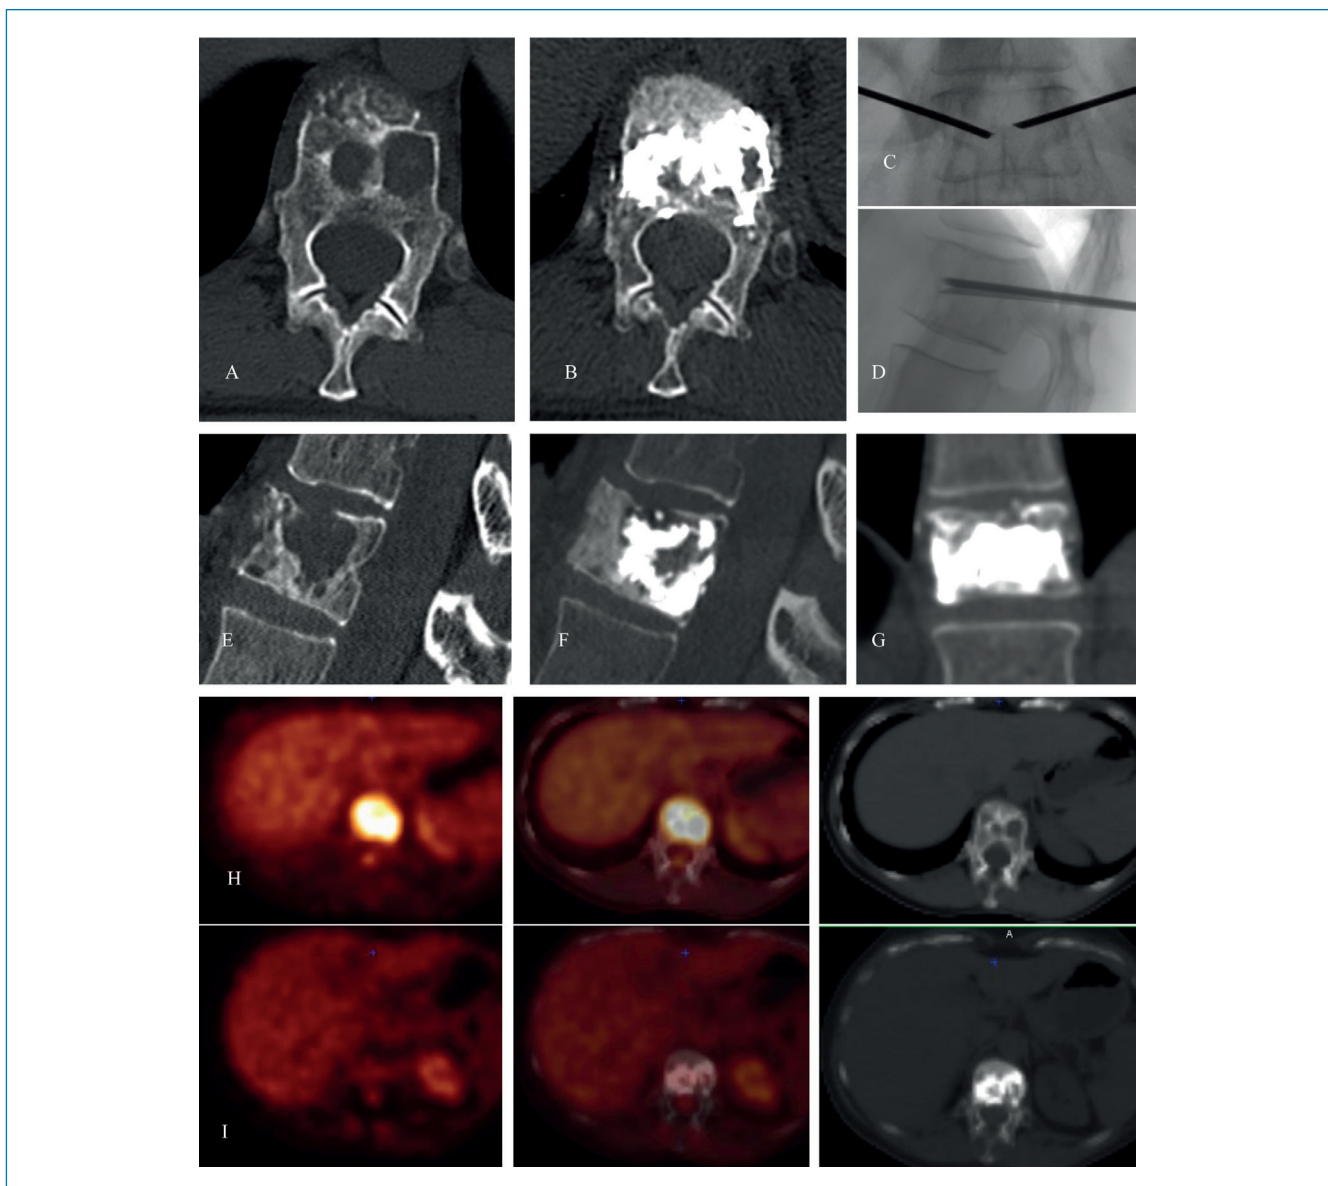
51-year-old female patient with a lytic metastasis (A, E) on T12 from breast cancer found at follow-up 30 months after mastectomy; the metastasis was the only FDG (fluorodeoxyglucose) uptake site at PET-CT (row H). The lesion was deemed stable and the patient had mild back discomfort but not significant pain. There was no indication for surgery. The MDT decision was to perform prophylactic vertebroplasty (C, D, B, F, G) to avoid any risk of post-irradiation vertebral collapse, and radiotherapy (30 Gy in 10 fractions). After two years of follow-up, zoledronic acid, ormonotherapy and different chemotherapeutic lines, FDG-PET still shows complete metabolic response on T12 (row I) despite the occurrence of lymph nodes, single sacral and single liver metastases.
